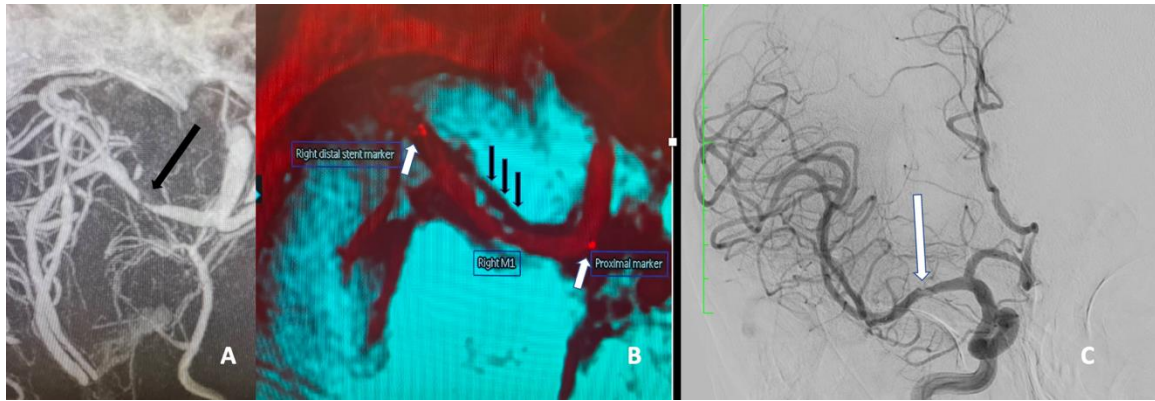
Smart CT Vaso image showed the site of intracranial atherosclerotic disease (long black arrow) (A). Fusion imaging MRI post gadolinium black blood with Intraarterial Smart CT Vaso image. The short white arrow showed the distal marker and proximal marker of Solitaire AB stent. The 3 short black arrows showed the atherosclerotic plaque appearance with stent in situ (B). Post intracranial M1 stenting angiographic image (image C) showed the area of atherosclerotic plaque after intracranial stenting (long white arrow).
